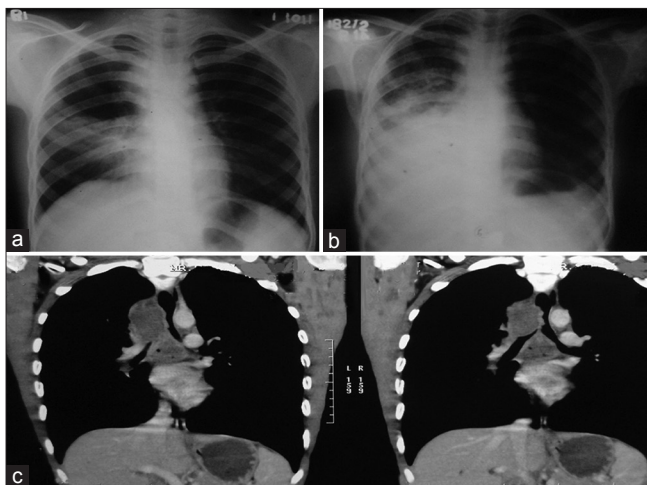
Chest X-ray PA view showing the right middle lobe consolidation (a) and the right sided pleural effusion with consolidation (b) CT scan thorax with contrast showing the necrotic lymph nodes in paratracheal and subcarinal sites (c)
